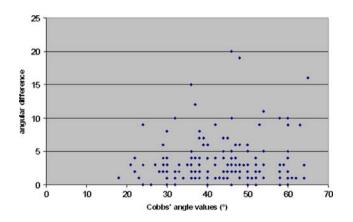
Graphic representation of the difference between the two series of measures using  $30 \times 90$  cm radiographs
